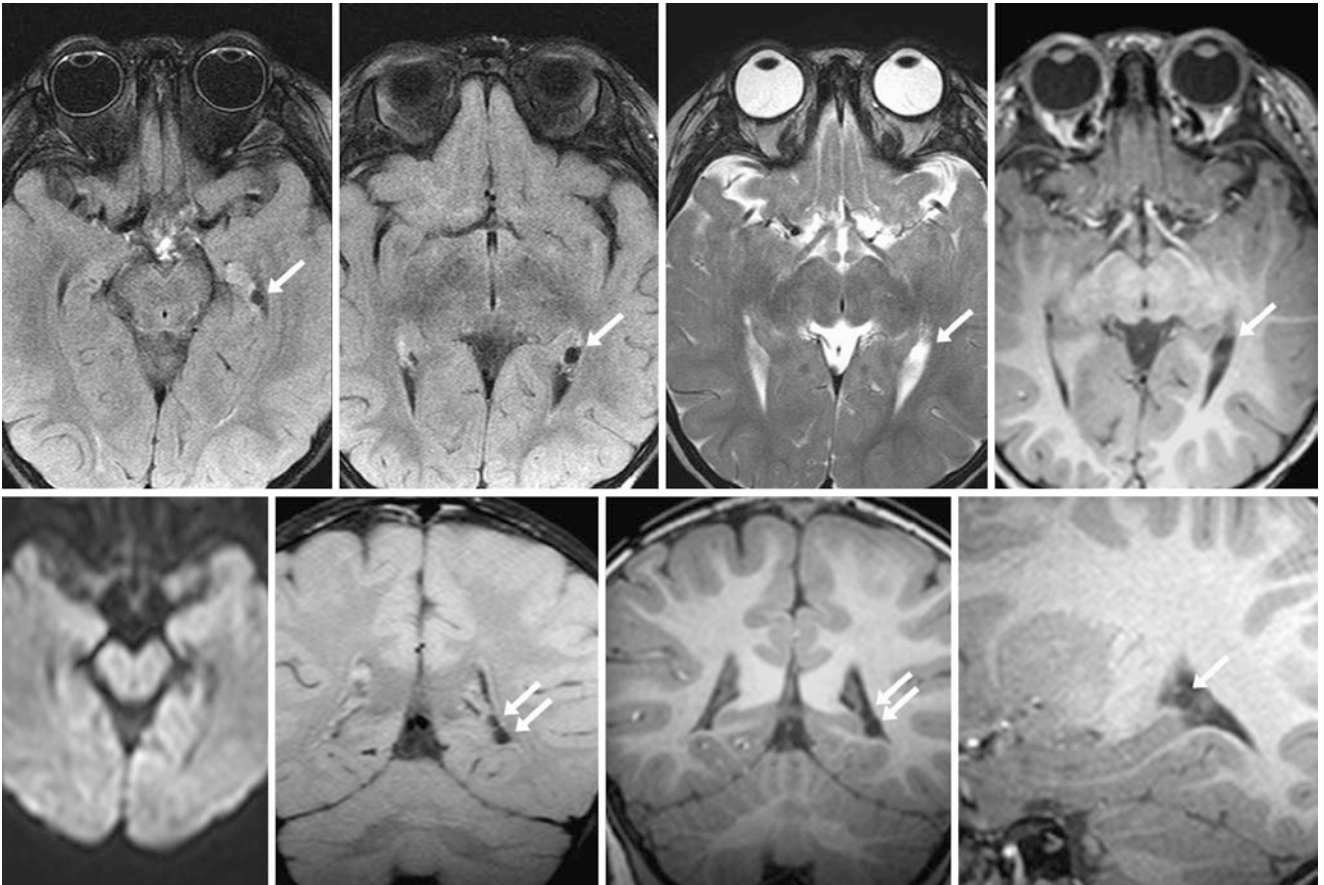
An 18-month-old infant with developmental delay and trisomy 21 who underwent a 3 T MRI. Two CPCs (arrows) within the left lateral ventricle were depicted on axial FLAIR (top, left, and left middle), axial T2WI (top, right middle), and axial T1WI (top right). Note
